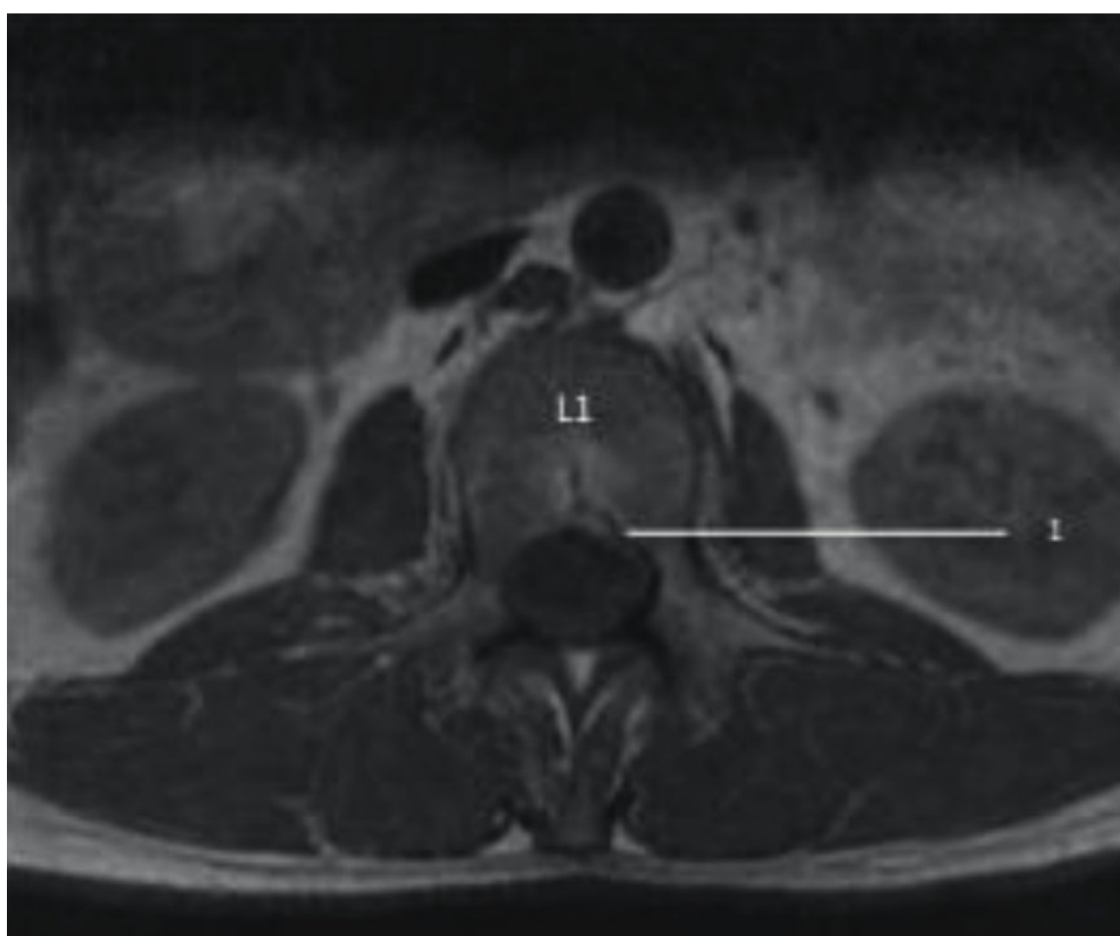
Magnetic resonance imaging axial cut at the L1 body. 1, bony defect consistent with compression fracture.
